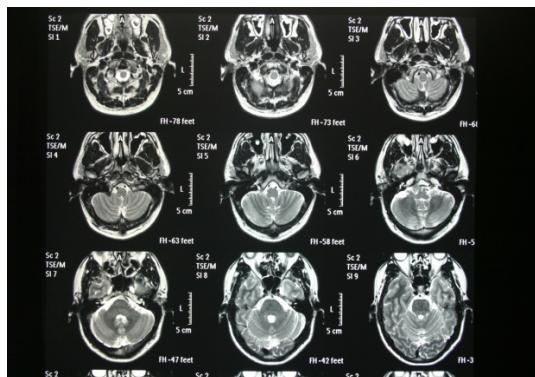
MRI on T2- weighted axial section ,compression of brainstem on left cerebellopontin angle by a vascular structure.(Multiple Images).
